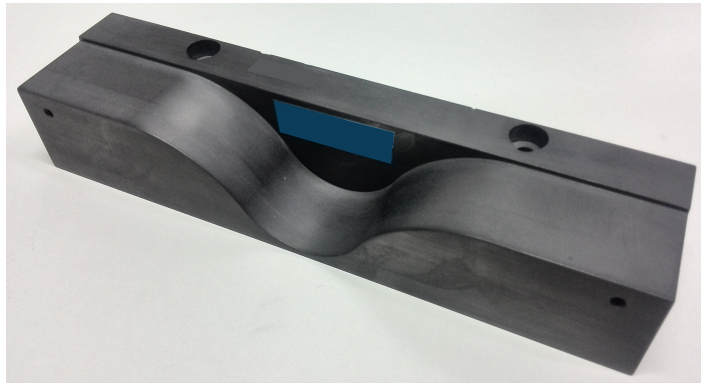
A static bowtie filter for x-ray fluence filtration. It is installed in the fan beam path inside the collimator box, see Figure 1.12. Depending on the fan beam angle  $\beta$ , the rays of the fan beam are attenuated when penetrating the wave-shaped solid. Central rays are hardly attenuated while the x-ray attenuation increases toward larger fan beam angles at the periphery. The transmission profile resulting from a static bowtie filter is pre-defined by its shape and material composition (e.g., aluminum). The straight part at the rear end (with two holes) is for the mounting.
